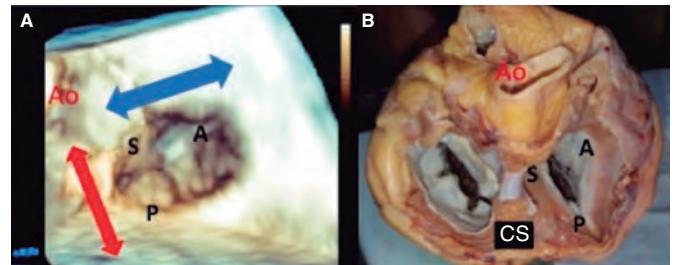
A: transesophageal echocardiogram in 3D zoom mode; periprocedural frontal view. The guide catheter can move inside the right atrium towards the aortic valve by advancing the entire system (red arrow) or towards the posterior leaflet by retracting it; the movement towards the septum (blue arrow) is possible through clockwise rotation of the guide catheter, and towards the right ventricle free wall through counterclockwise rotation. B: explanted heart, anatomic view. A, anterior; Ao, aorta; P, posterior; S, septal; CS, coronary sinus.
